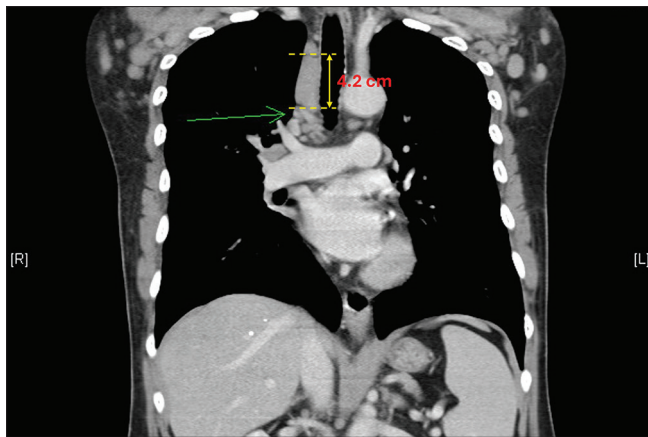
Computed tomography showed disseminated enlarged lymphadenopathies. This figure shows enlarged mediastinal lymph nodes (green arrow), with the largest node measuring 4.2 cm
